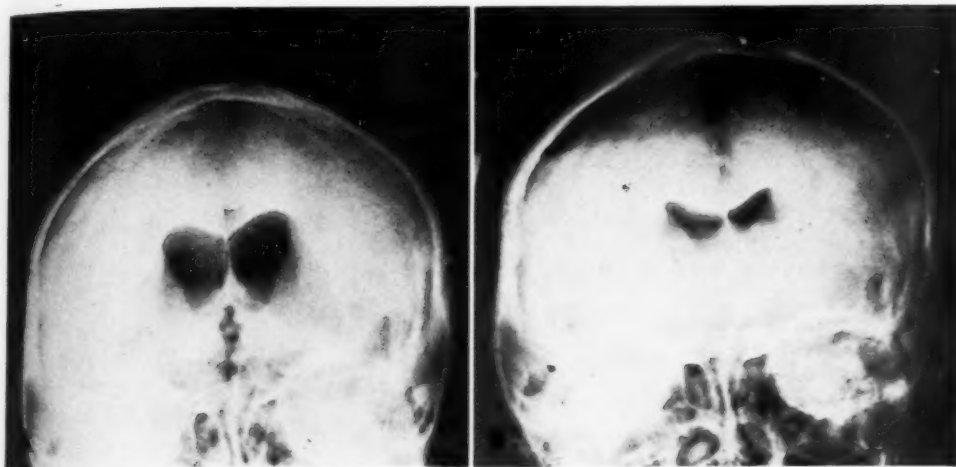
A. Immediate pneumoencephalogram, showing no subdural gas except for a trace under the tentorium. B. Twenty-four-hour roentgenogram, showing large subdural gas accumulations over convexity, with fluid levels. The decrease in size of the lateral ventricles is striking.
